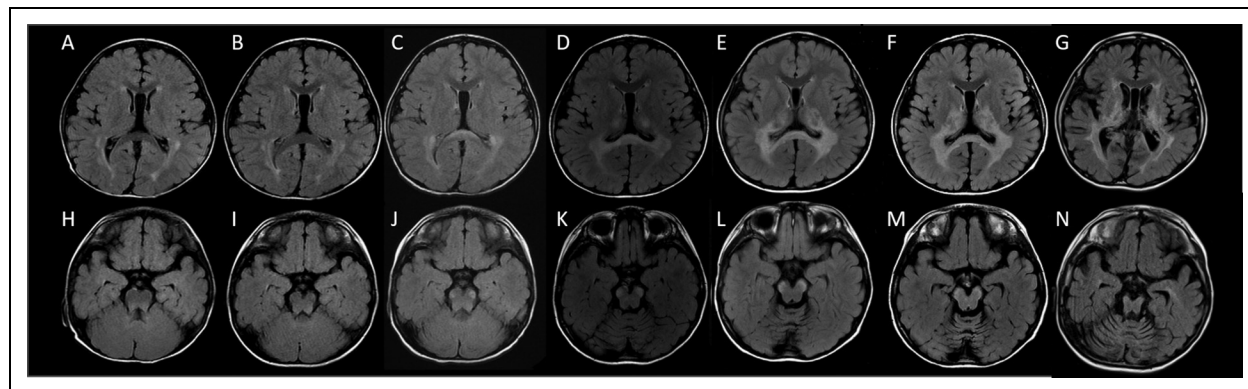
Changes in brain MRI findings with age. Panels show axial images of fluid-attenuated inversion recovery (FLAIR) brain MRI from 1 year 8 months to 6 years 2 months of age. Images were obtained at 1 year 8 months (A and H), 2 years 11 months (B and I), 3 years 7 months (C and J), 4 years 1 month (D and K), 4 years 6 months (E and L), 5 years 1 month (F and M), and 6 years 2 months (G and N). White matter dystrophy was initially observed predominantly in the occipital lobe, and the lesion gradually spread to the corpus callosum ampulla, brainstem, and basal ganglia. Cerebral and cerebellar atrophy with a predominance in the vermis was also progressive with age.
